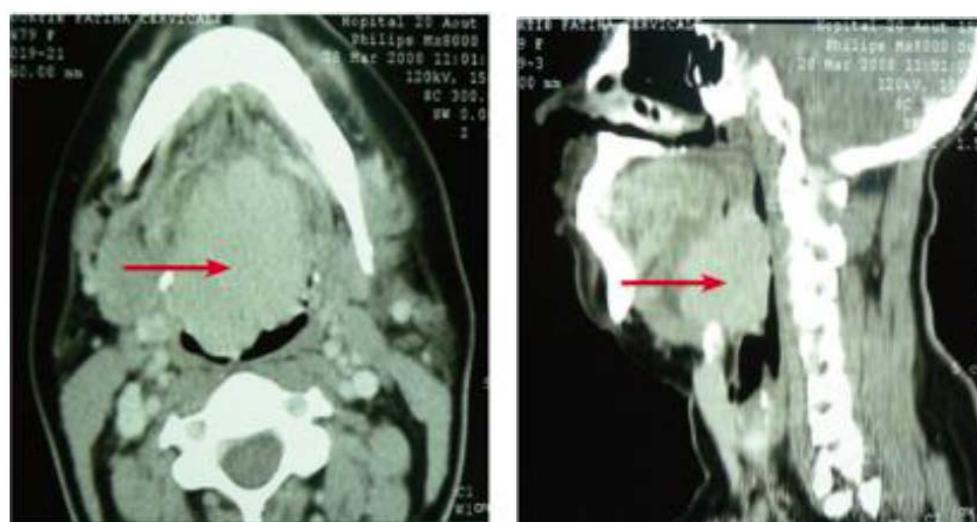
CT-scan of the neck showed a large epiglottic mass extending to the base of the tongue and protruding to the oropharyngeal area.
